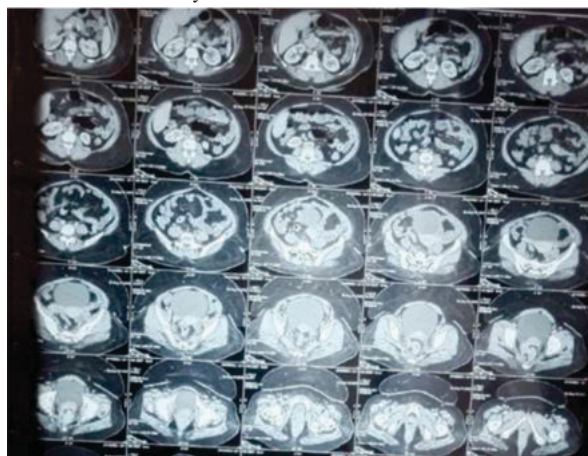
CONTRAST CT ABDOMEN AND PELVIS showing the rectum and anal canal growth
